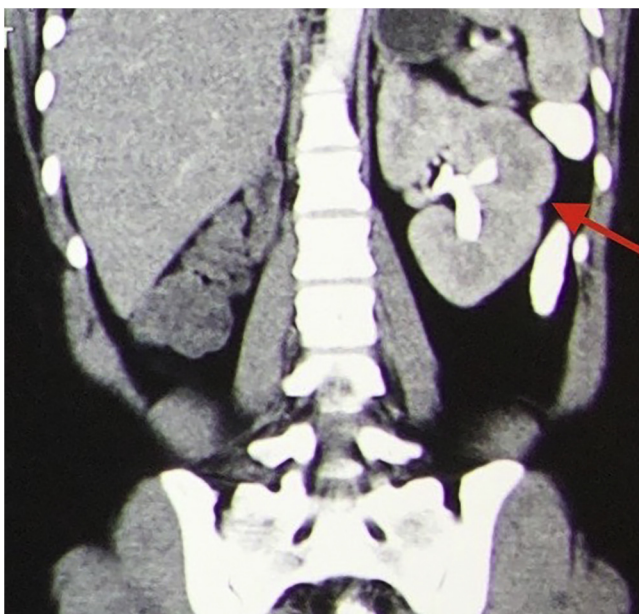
Coronal section of CT scan revealed normal structure of left kidney and agenesis of right kidney.
